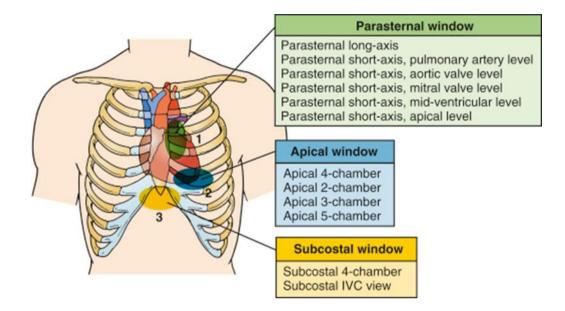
Image showing transthoracic echocardiographic windows: parasternal long-axis, parasternal short-axis, apical, and subcostal (Millington, 2014).
